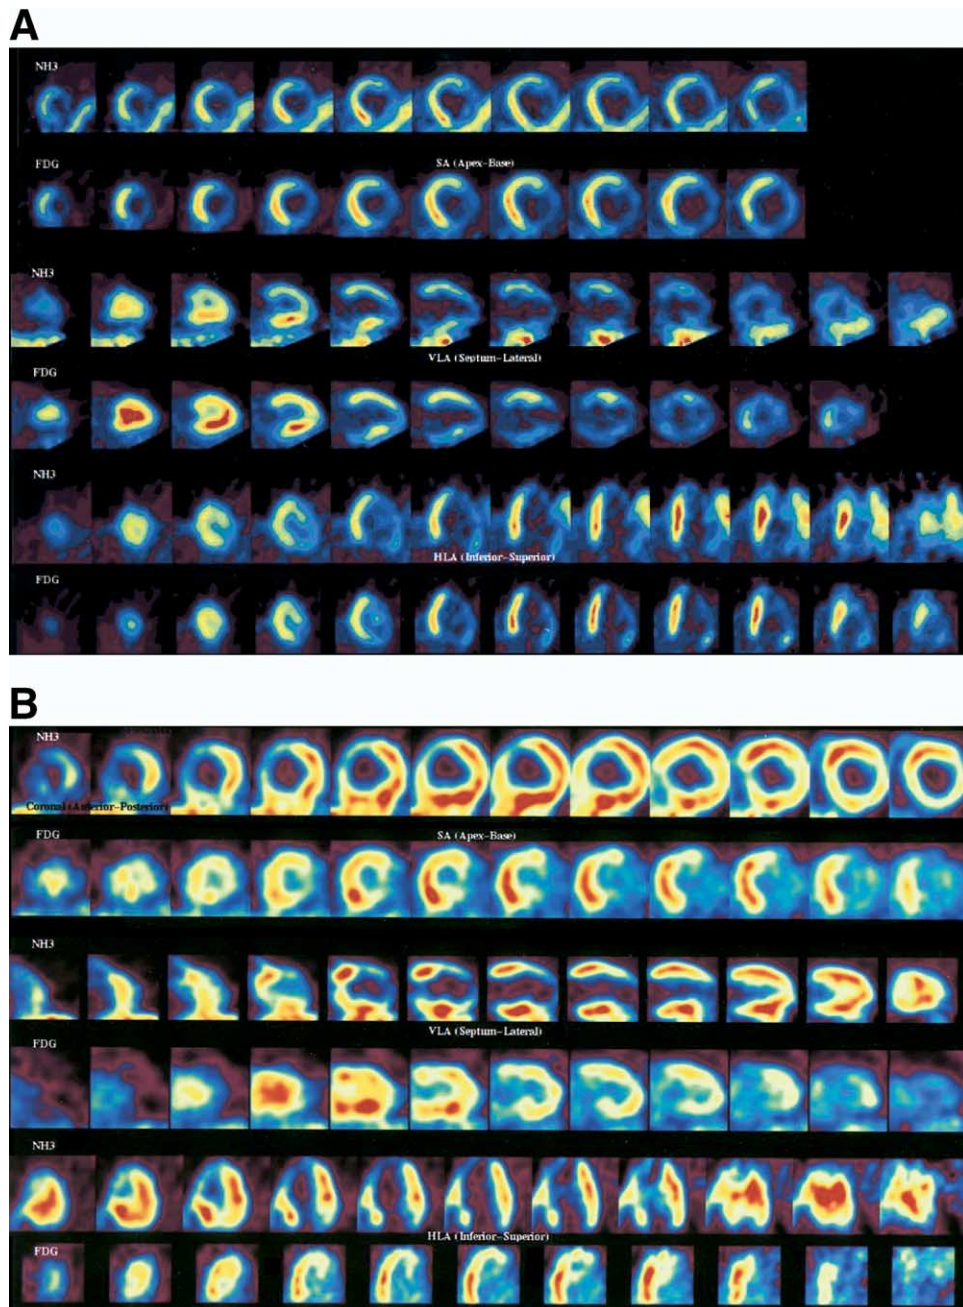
PET tomograms obtained showing standard reconstructions with resting ^{13}N ammonia images on the top and ^{18}F FDG images below. In this color scheme, red represents the highest counts with blue–black representing the lowest counts per pixel. A, PET image of infarction. Patient with large anterolateral and inferior perfusion defects that have concordantly decreased FDG uptake consistent with a large circumflex and/or right coronary artery infarction. In the ^{13}N ammonia images, the uptake seen at the lower right represents ^{13}N ammonia uptake into lungs, which frequently is seen in patients with congestive heart failure. There is some evidence of viability in the left anterior descending coronary artery territory with diminished perfusion and slightly increased FDG uptake. B, PET images of significant viable myocardium. There are large anteroapical and lateral perfusion defects seen in the ^{13}N ammonia study with intense FDG uptake in areas of hypoperfusion representing near complete viability in these areas.
